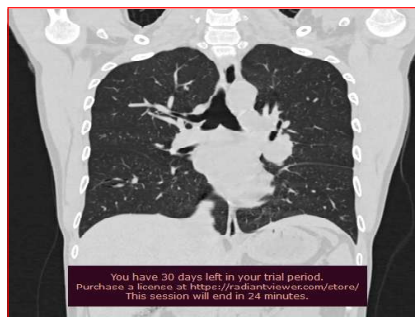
Computed tomography (CT) of the chest (coronal cut, lung window) showing right tracheal bronchus
